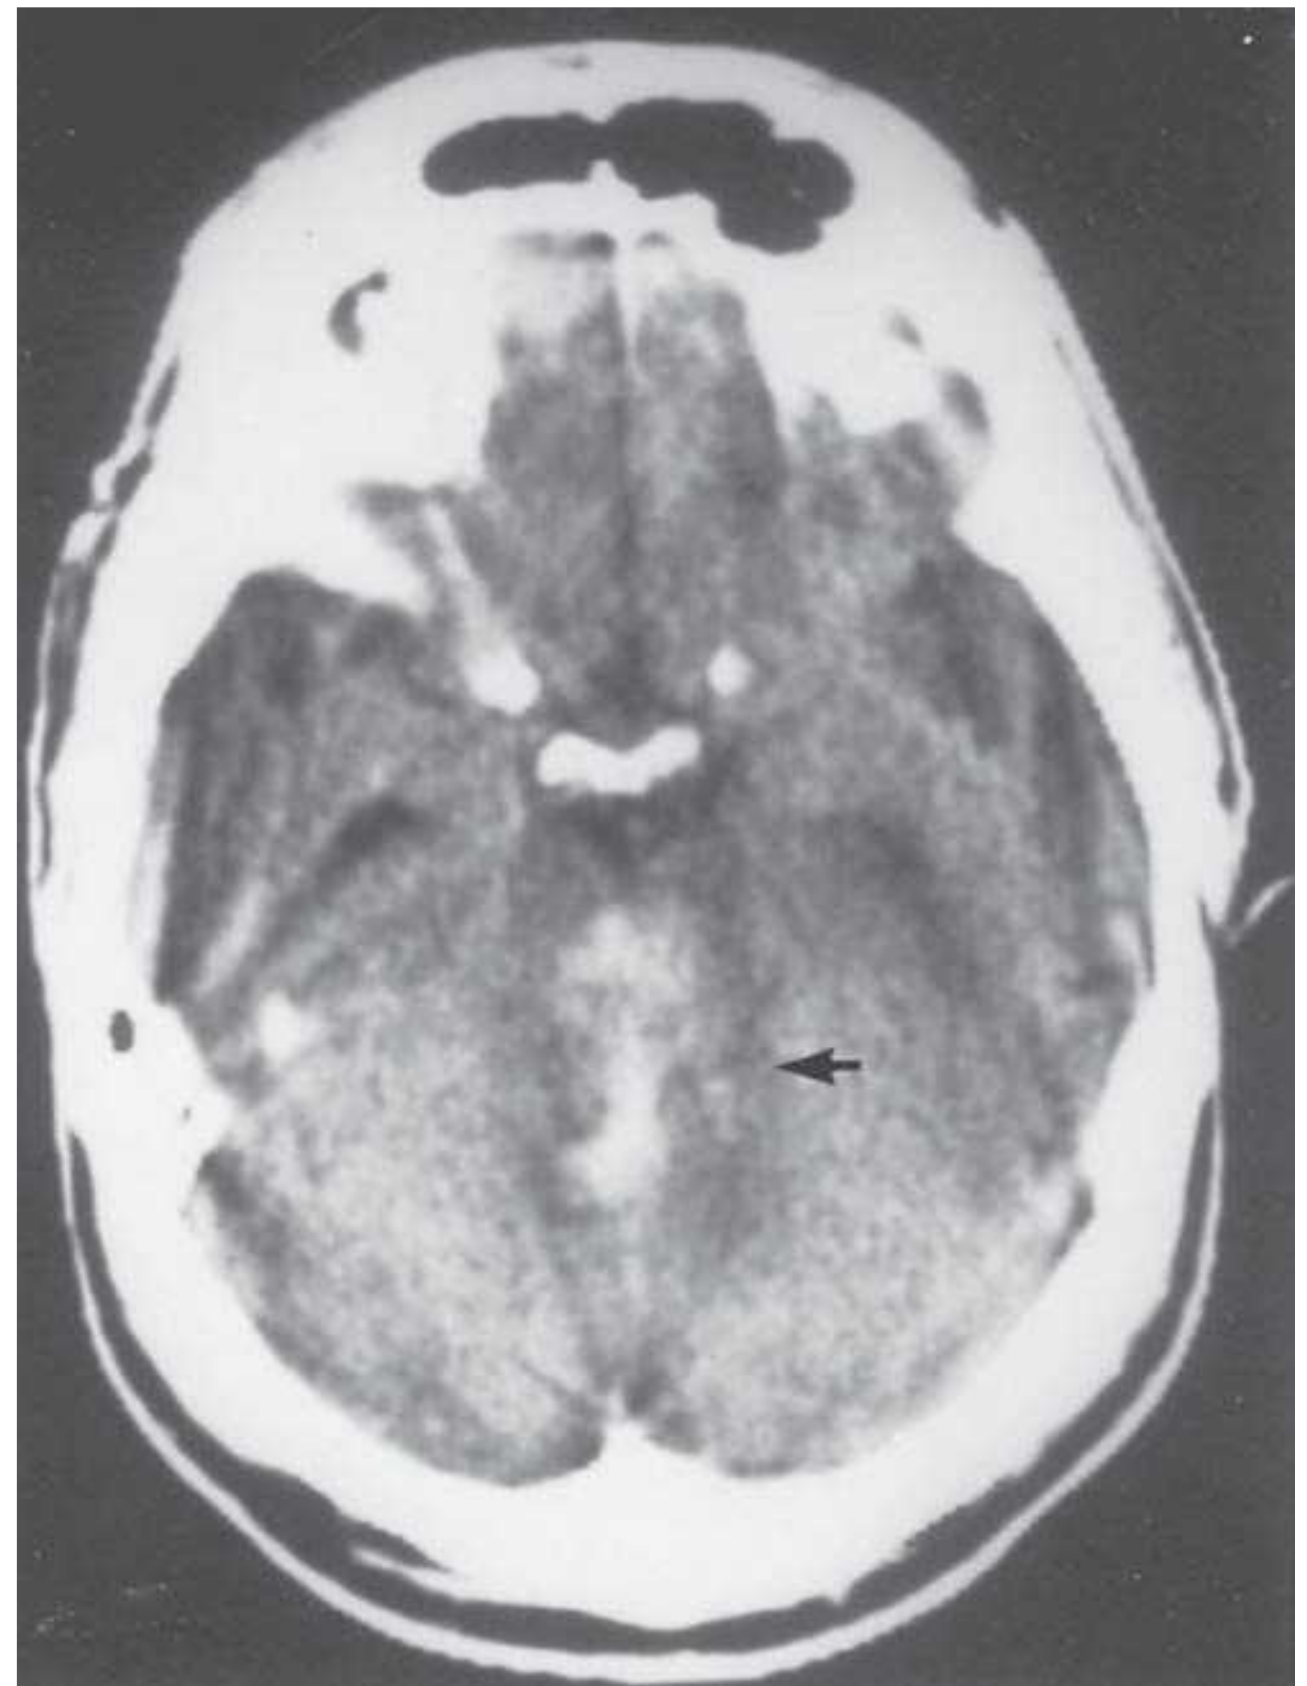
Midline cerebellar hemorrhage (arrow) seen on a computed tomography scan.
